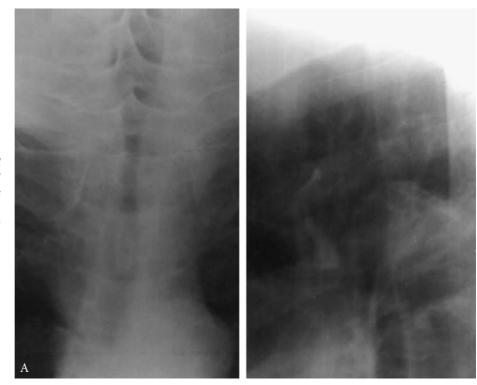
Saber-sheath trachea. A, Anteroposterior (left) and lateral (right) roentgenograms, showing normal appearing cervical trachea with side-to-side narrowing of the intra-thoracic trachea. Near the carina, the trachea begins to widen again.
